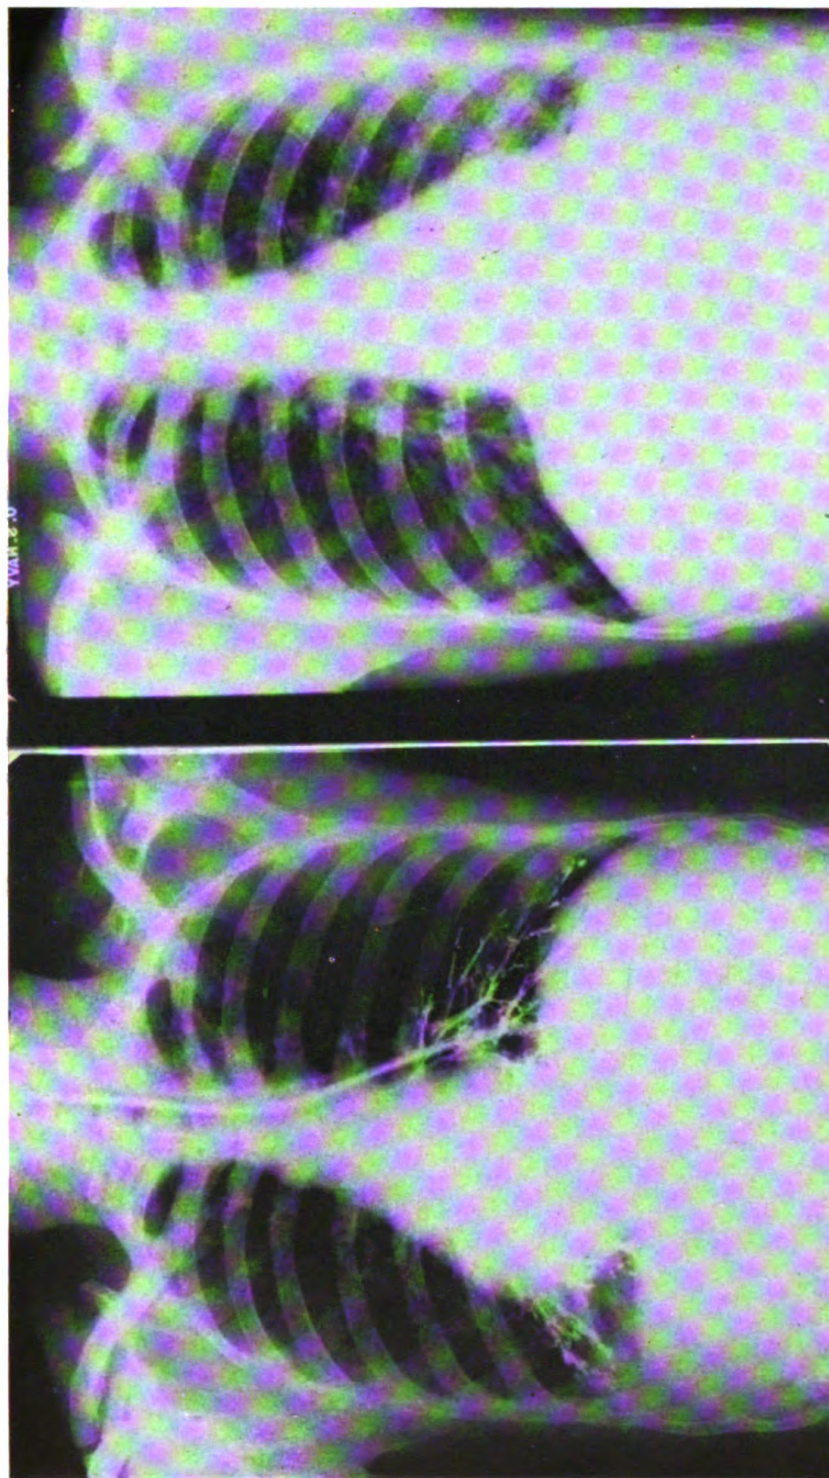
(LEFT) LIPIODOL INJECTION SHOWING EARLY BRONCHIECTASIS BOTH LOWER LOBES. (RIGHT) PLAIN FILM SHOWING SAME THING AND PLEURISY OF LEFT LOWER LOBE.
